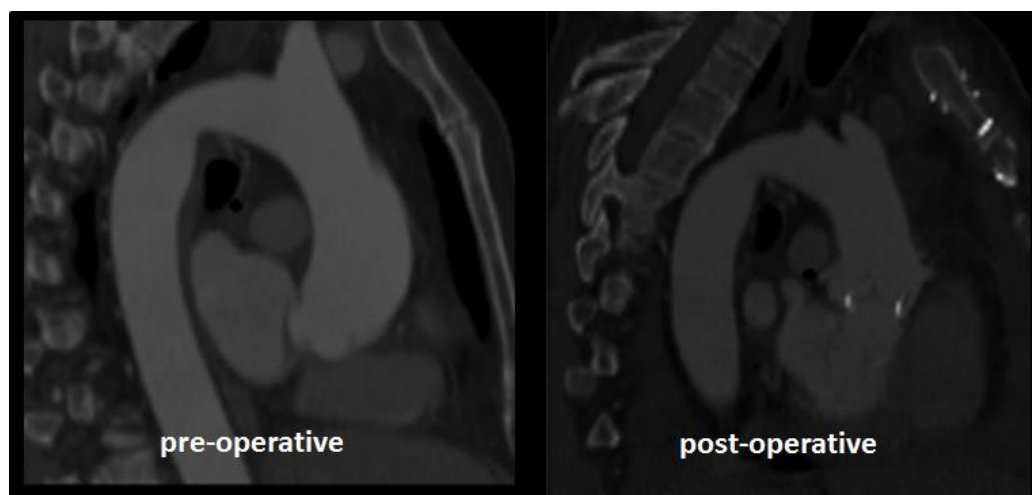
Pre- and post-operative CT images showing the change in the aortic shape induced by surgical remodeling.
